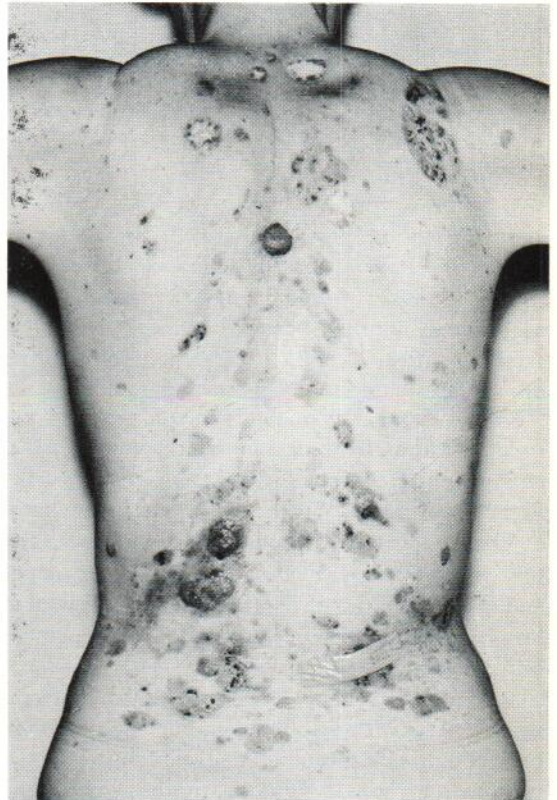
Woman aged 35 with multiple nevoid basal cell carcinoma syndrome: The first nevus-like basaliomas were observed when she was 4 years old. Treatment: radiotherapy, electrocaustic scraping, lapis, colchicine ointment, podophyllin ointment, etc. At the top the ugly roentgen scars are visible.
